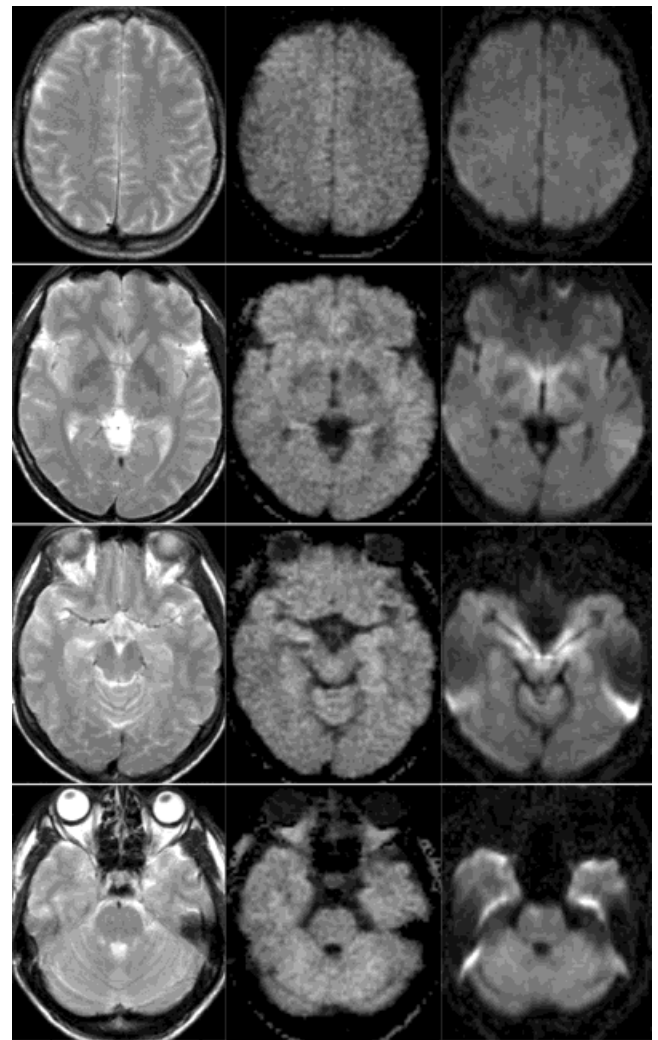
DW MRI of the human brain in four sections (6 mm thickness) with different degrees of susceptibility affection. Left: Anatomic fast SE images (TR/TE = 2500/98 msec); middle: isotropic DW STEAM images ( $2.0 \times 2.0 \text{ mm}^2$ ,  $b = 1000 \text{ sec mm}^{-2}$ , other parameters as in Fig. 3); and right: isotropic DW EPI images ( $2.0 \times 2.7 \text{ mm}^2$ ,  $b = 1000 \text{ sec mm}^{-2}$ ).
